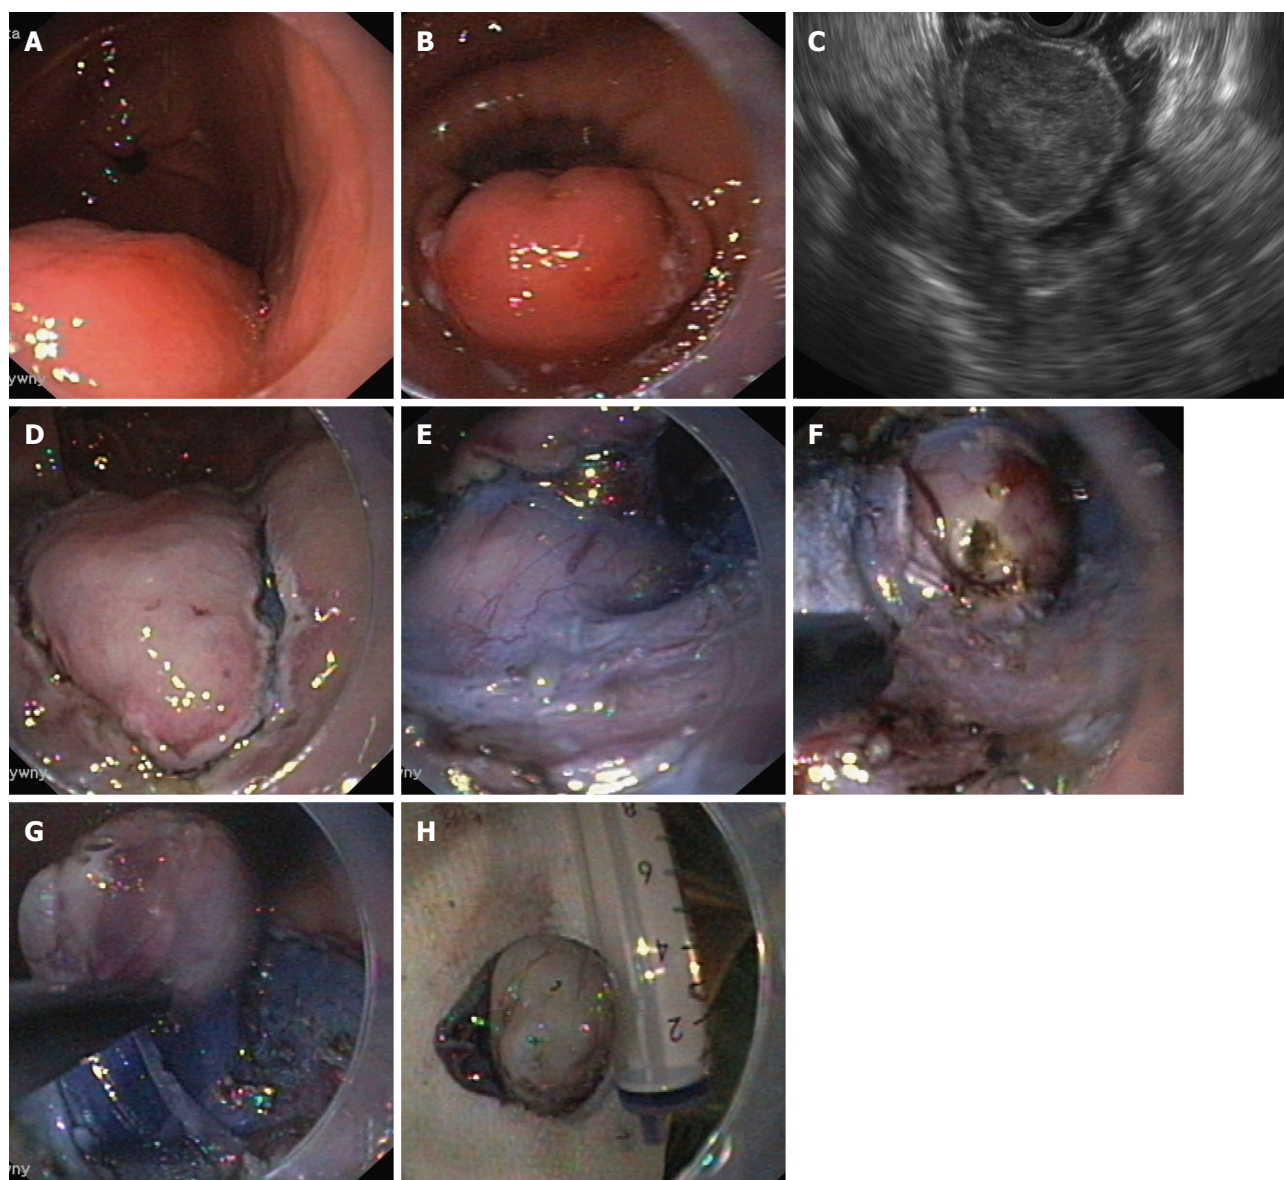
Endoscopic submucosal dissection of gastric submucosal tumor. A, B: Submucosal tumor in the stomach; C: Endosonographic view of the tumor, which is not connected to the muscle layer of the gastric wall; D: An incision was made in the mucosa and submucosa after indigo carmine solution injection into the submucosal layer around the lesion; E-G: Submucosal dissection of the tumor, exposing the tumor in the submucosa and carefully cutting after injecting the solution; H: Resected tumor (GIST, 25 mm, MI 2/50 HPF). GIST: Gastrointestinal stromal tumor; MI: Mitotic index; HPF: High power field.
